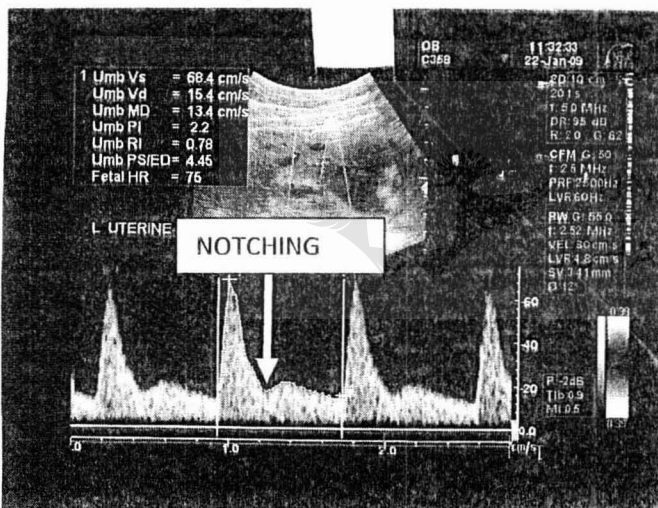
Demonstrating an abnormal uterine artery Doppler waveform noted with notching and a high PI. (Researchers collection)
